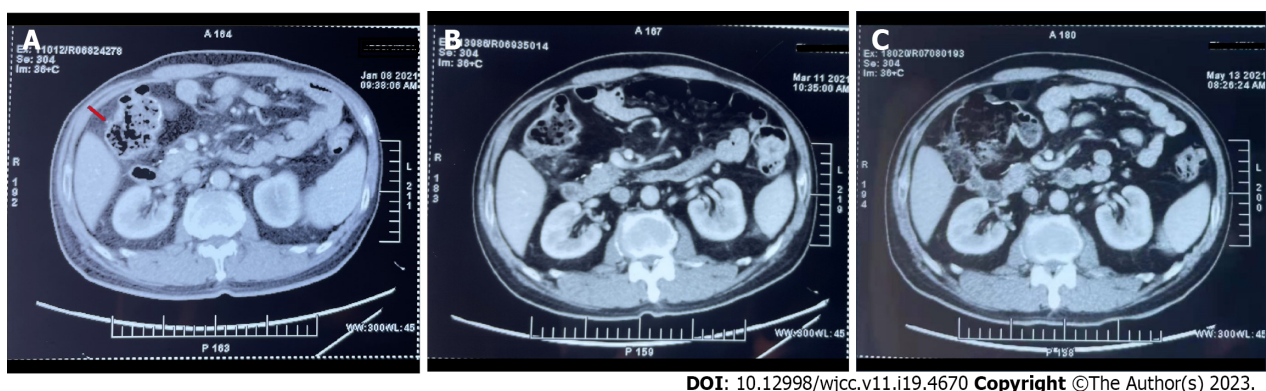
Computed tomography before and after traditional Chinese medicine. The patient presented to our hospital after receiving eight cycles of adjuvant chemotherapy with oxaliplatin and capecitabine. A: Initial computed tomography results revealing pelvic metastasis near the anastomotic stoma of the transverse colon, with a size of approximately 1.4 cm × 0.9 cm; B and C: Traditional Chinese medicine led to a gradual reduction in the tumor size according to the re-examinations performed 2 mo (B) and 4 mo (C) after presentation.
